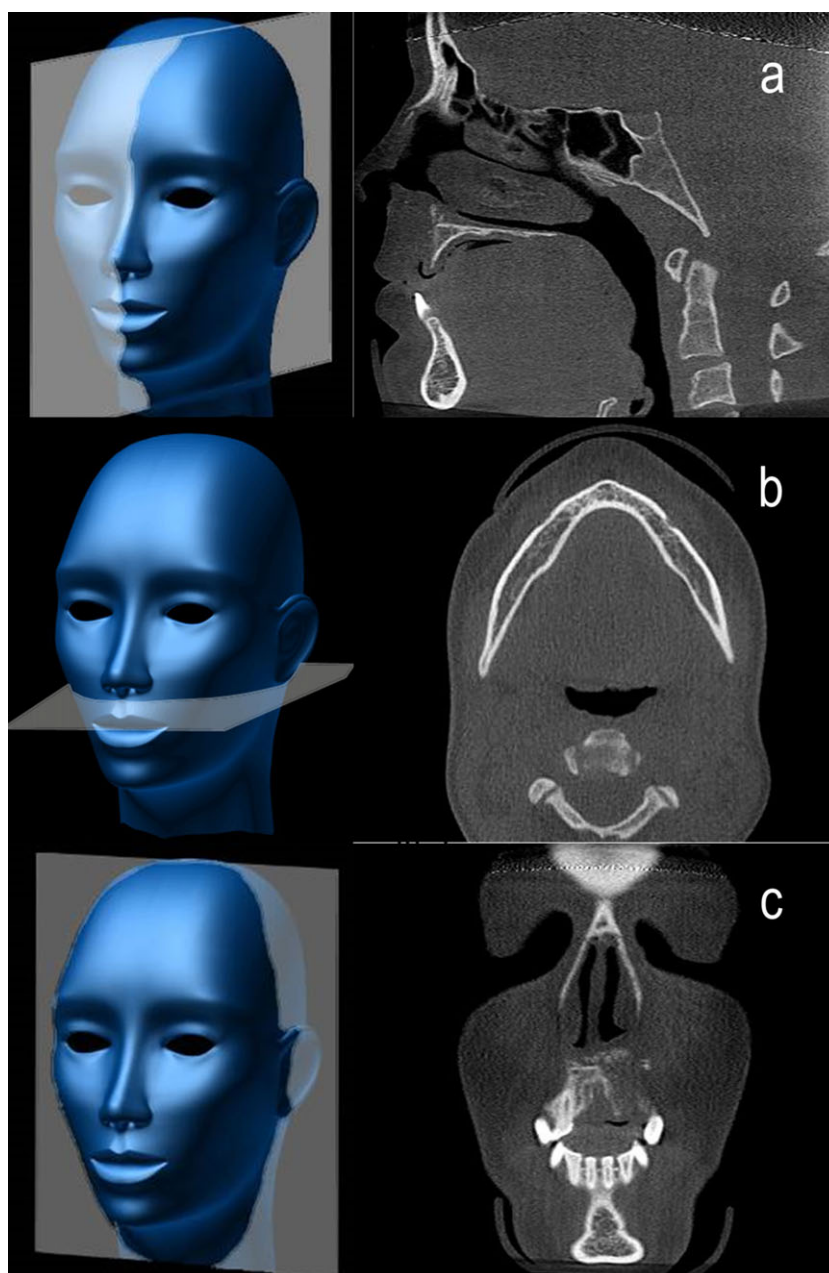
Secondary reconstruction of CBCT projection data provides a volumetric dataset. The default display of a dataset are as contiguous uniform image sections in three perpendicular (orthogonal) planes - sagittal (a), axial (b) and coronal (c).
